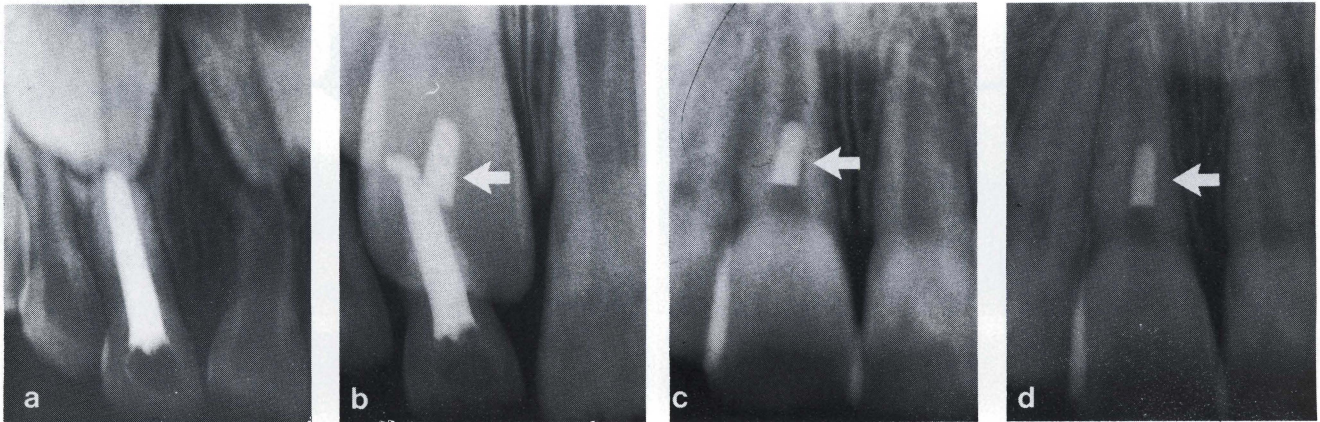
a-d. These four radiographs show the interesting movement of a partly resorbed filling. The most recent view (D) when shown to an unknowing observer stimulates interesting comments.
